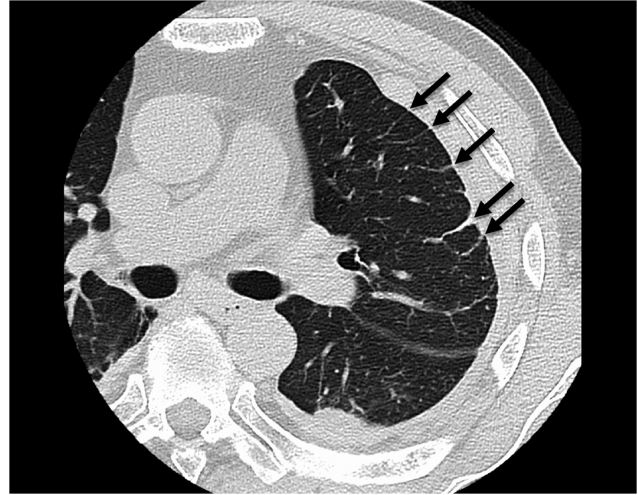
A cross-sectional chest computed tomography (CT) image showing the presence of the “crow’s feet” sign in the pleural effusion site.
